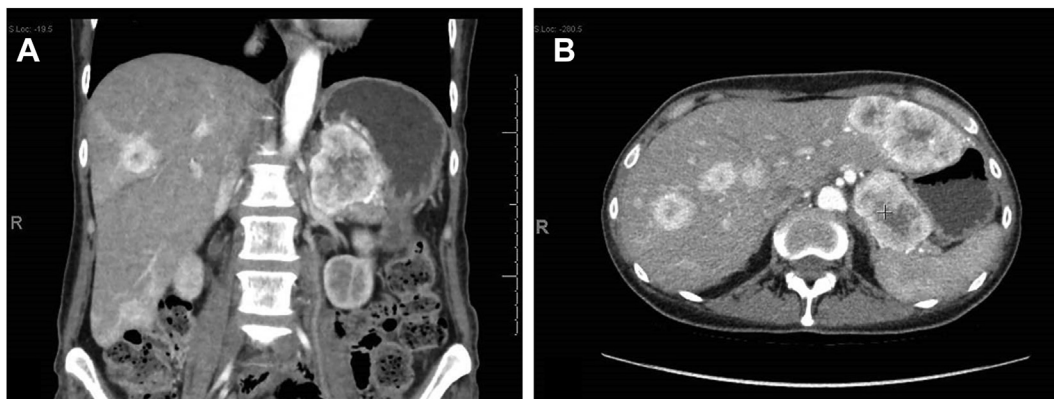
Computed tomography with contrast demonstrating the pancreatic neuroendocrine tumor in the tail of the pancreas and numerous liver metastases. A, Coronal section. B, Axial section. These images were taken 6 months after diagnosis.
